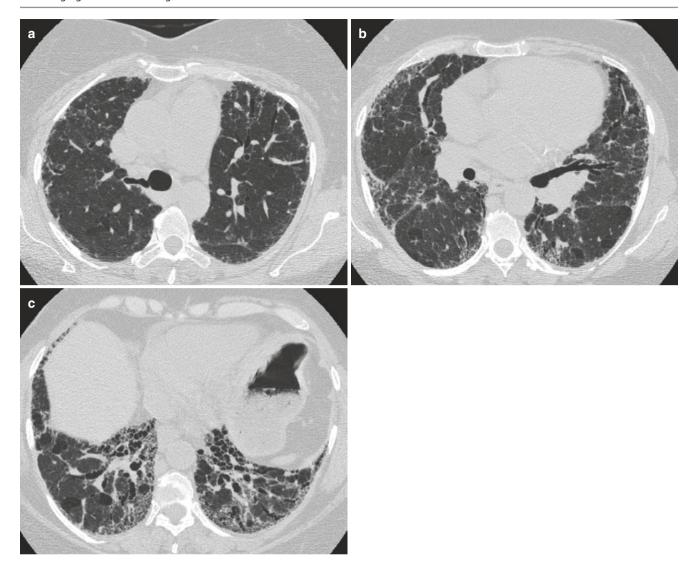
CT pattern indeterminate for UIP. (a–c) Axial CT images show lower lung predominant fibrotic lung disease with reticular opacities and traction bronchiectasis but no honeycombing. However, due to
